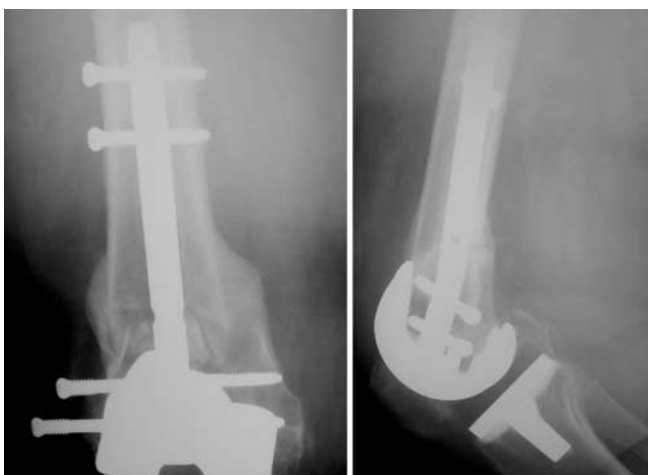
Radiographs of the knee showing complete fracture union after supracondylar nailing. Note loosening of the distal screws, which were subsequently removed
